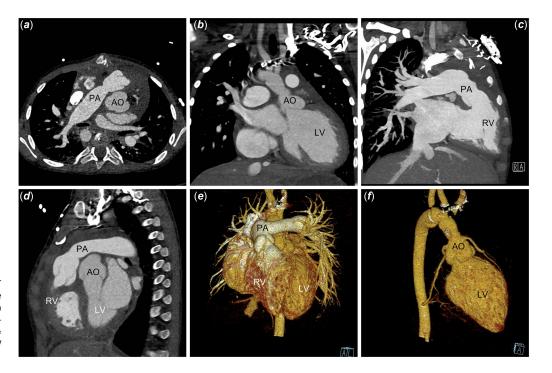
Postoperative cardiac CT revealed the pulmonary artery on the front and right side of the aorta (a), with the pulmonary artery and aorta anatomically correct (b-f). AO = aorta; PA = pulmonary artery; LV = left ventricle; RV = right ventricle.
